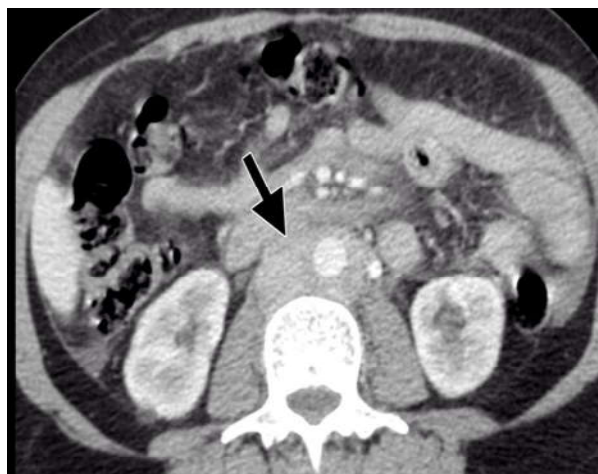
CT Abdomen Axial view of Non-Hodgkin’s lymphoma Case [21]
